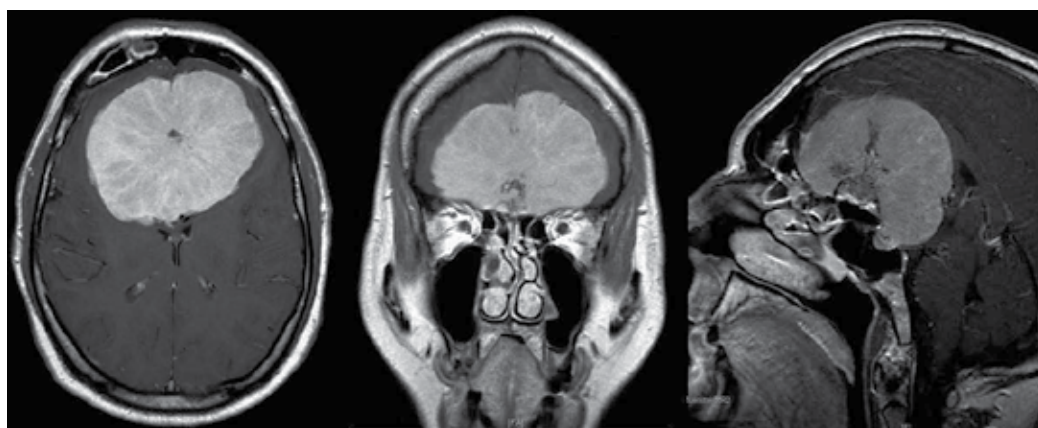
T1-weighted triplanar magnetic resonance tomography after application of gadolinium, revealing a huge tuberculum sellae meningioma with homogenous contrast enhancement
